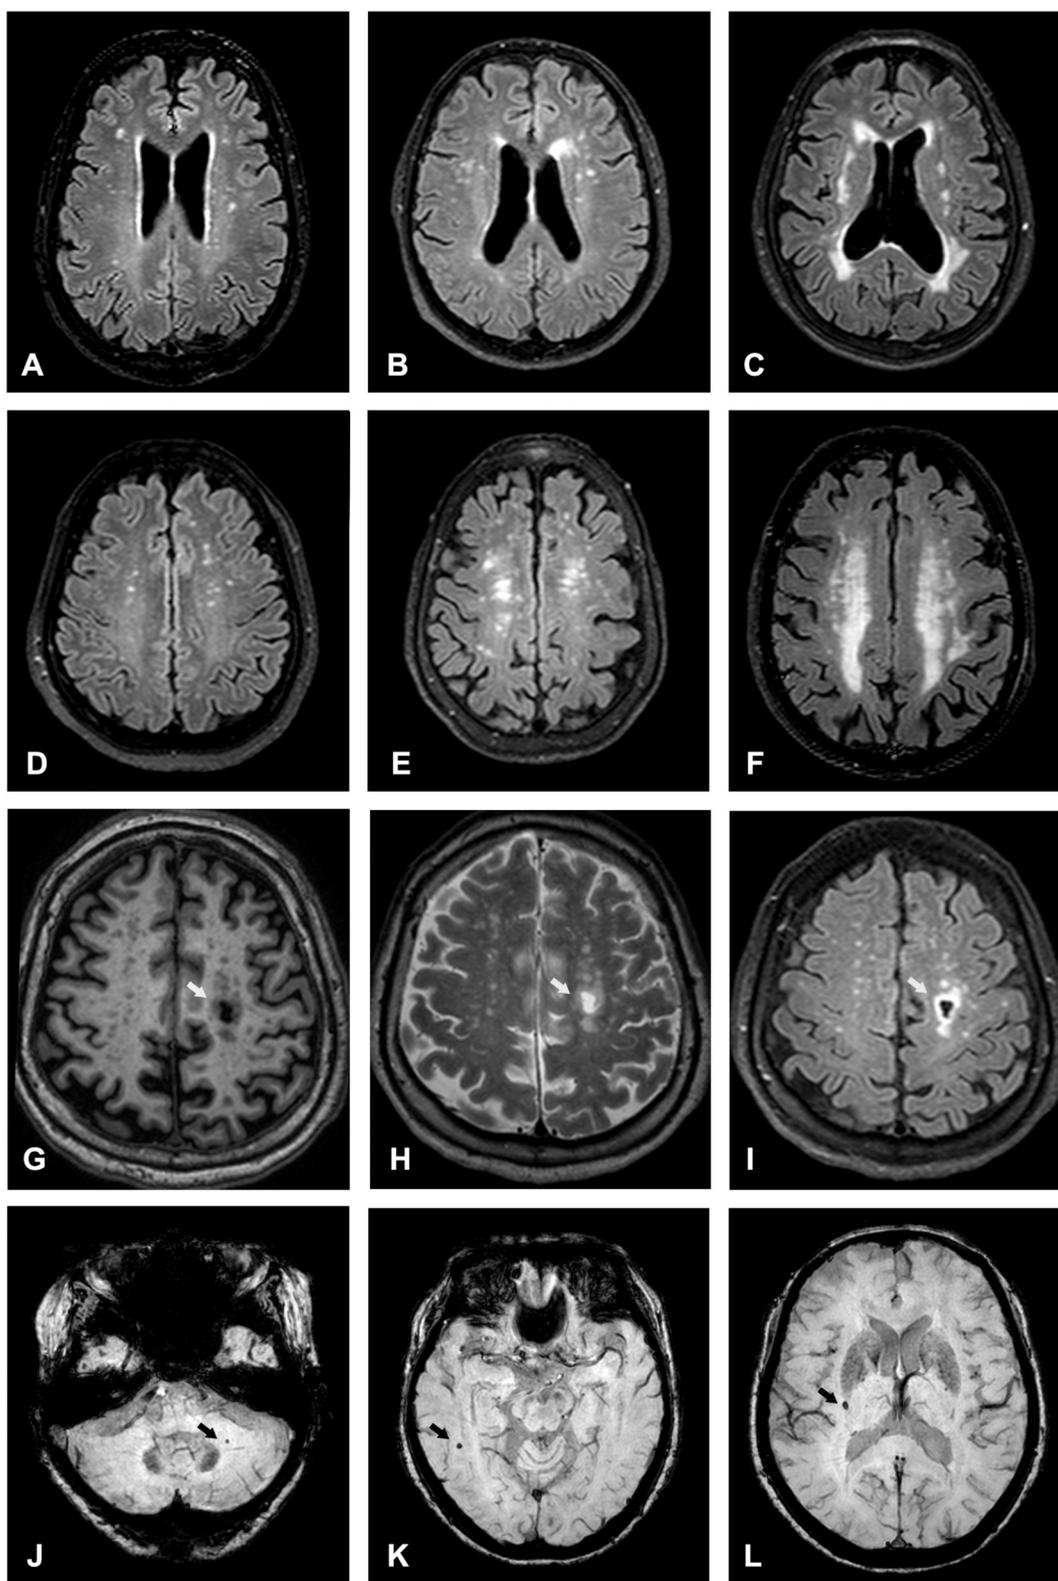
These FLAIR images show increasing degrees of periventricular hyperintensities (A, B and C) and deep white matter hyperintensities (D, E and F) as rated on the Fazekas scale. The T1-weighted (G), T2-weighted (H) and FLAIR (I) images show the same silent lacune. Three microbleeds of different locations (J, cerebellum; K, temporal lobe and L, basal ganglia) are shown on susceptibility-weighted imaging.
